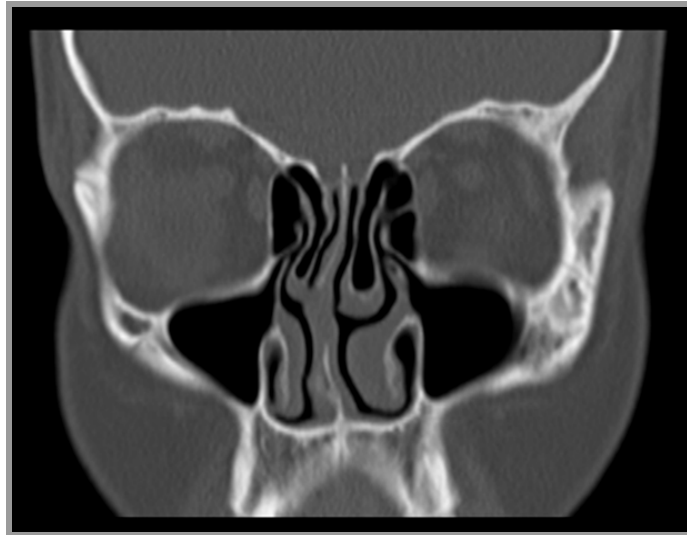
Coronal CT image showing the uncinate process
